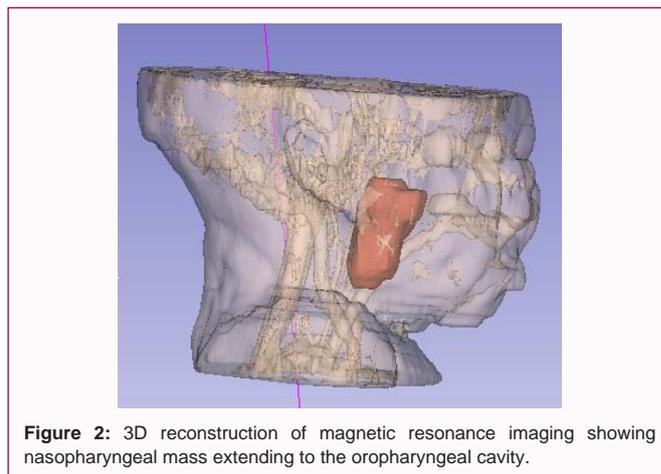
3D reconstruction of magnetic resonance imaging showing nasopharyngeal mass extending to the oropharyngeal cavity.
